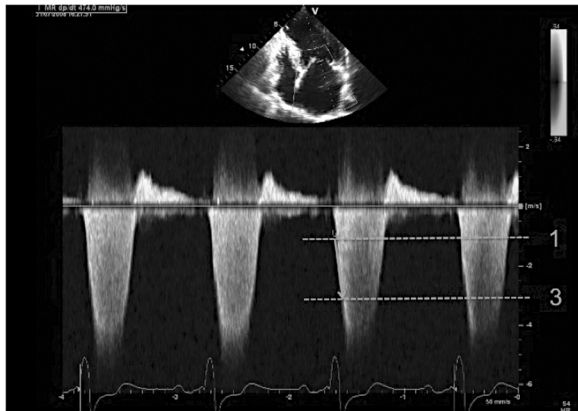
Contractility dP/dT. The panel shows a mitral valve regurgitation signal by continuous wave (CW) Doppler. Change in velocity is measured, by definition, between 1 and 3 m/sec. The dP/dT is 474 msec, and implies severely diminished LV function.
